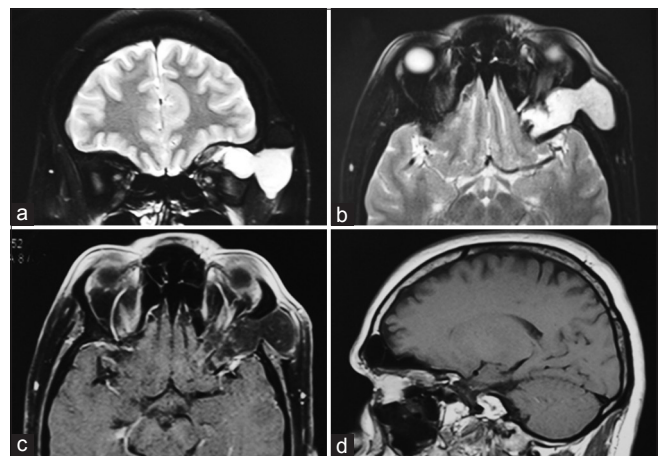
Magnetic resonance imaging showing heterogeneously enhancing mixed intensity dumb-bell shaped lesion with fat-fluid level (a) enhancement postcontrast (b) noticed in the left orbit along the superolateral aspect with medial end extending up to the superior orbital fissure and anterior cavernous sinus (c), extension of the lesion into the anterior cavernous sinus can be seen on sagittal section (d)
